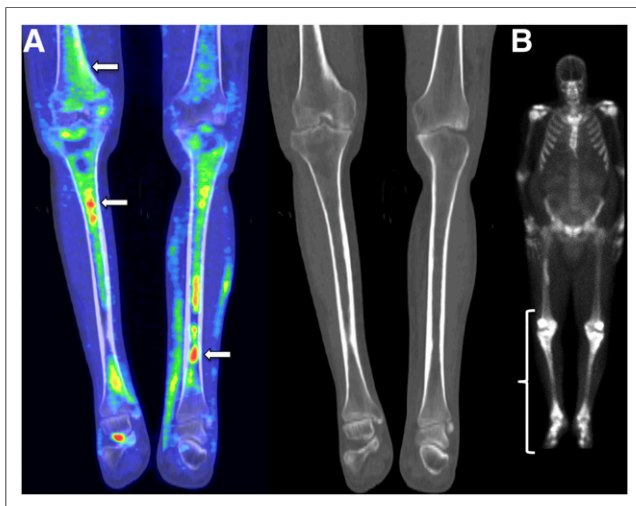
(A) Coronal ^{18}F -FDG PET/CT of distal lower extremities demonstrates ^{18}F -FDG-avid disease within both tibiae and distal femur (arrows) without osteosclerosis. (B) Anterior planar $^{99\text{m}}\text{Tc}$ -methylene diphosphonate whole-body bone scan demonstrates increased uptake throughout both distal lower extremities (bracket).
